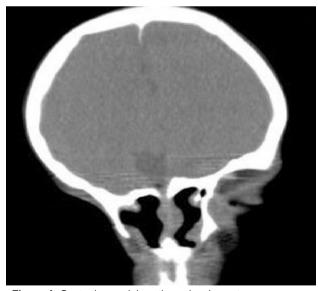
Contagious axial sections showing cutaneous osseocartilagenous nasal defect; Coronal CT showing right cribiform plate defect and para-sagittal arachnoid cyst.
